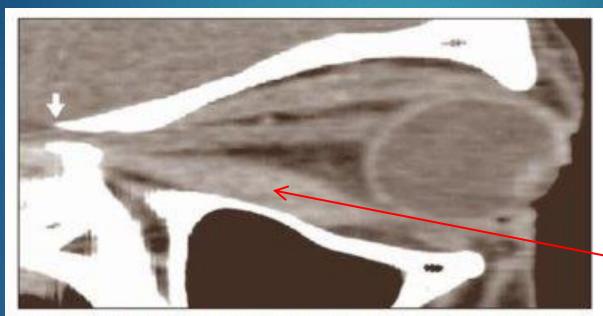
Sagittal CT image showing the optic nerve stretching resulting from proptosis and compression in the region of the orbital apex (arrow). Note the thickening of the inferior rectus muscle and the superior muscle complex.
